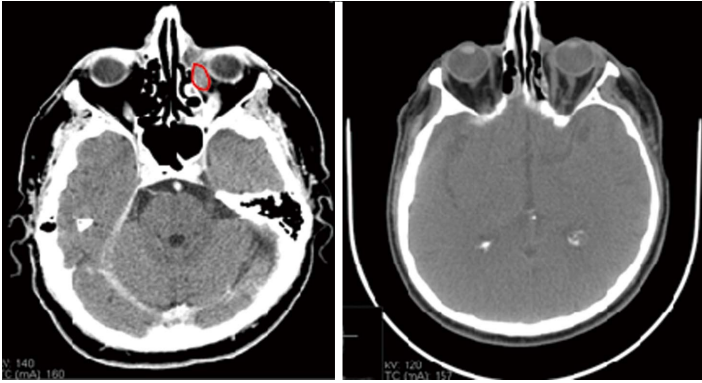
Computed tomography scan showed an intraorbital lesion (May 2012).
